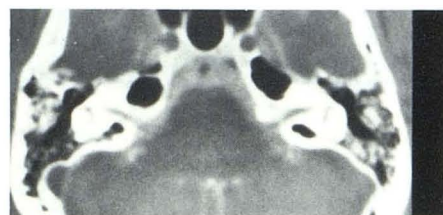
Anteverted internal auditory canals in association with pneumatization of petrous bone. Coronal CT, also with metrizamide, as well as pluridirectional tomography, demonstrated marked narrowing of both canals.
